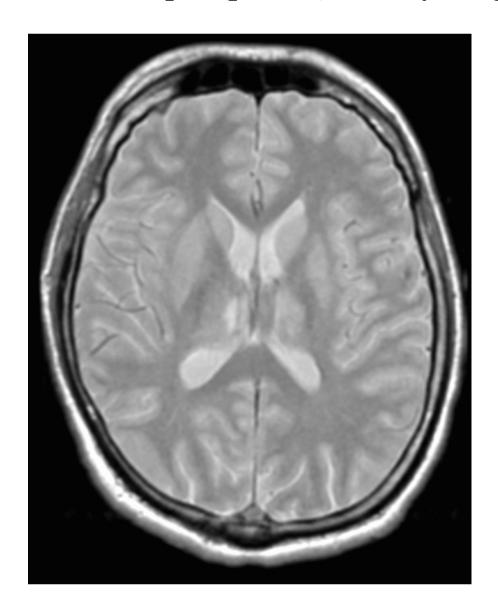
The proton density-weighted axial spin echo brain image, obtained with TR= 2400 msec and TE= 30 msec, shows reduced contrast compared with the T1-weighted images (but an overall higher signal amplitude). Tissues with higher spin density (e.g., fat, cerebrospinal fluid (CSF)) have higher image intensity.
